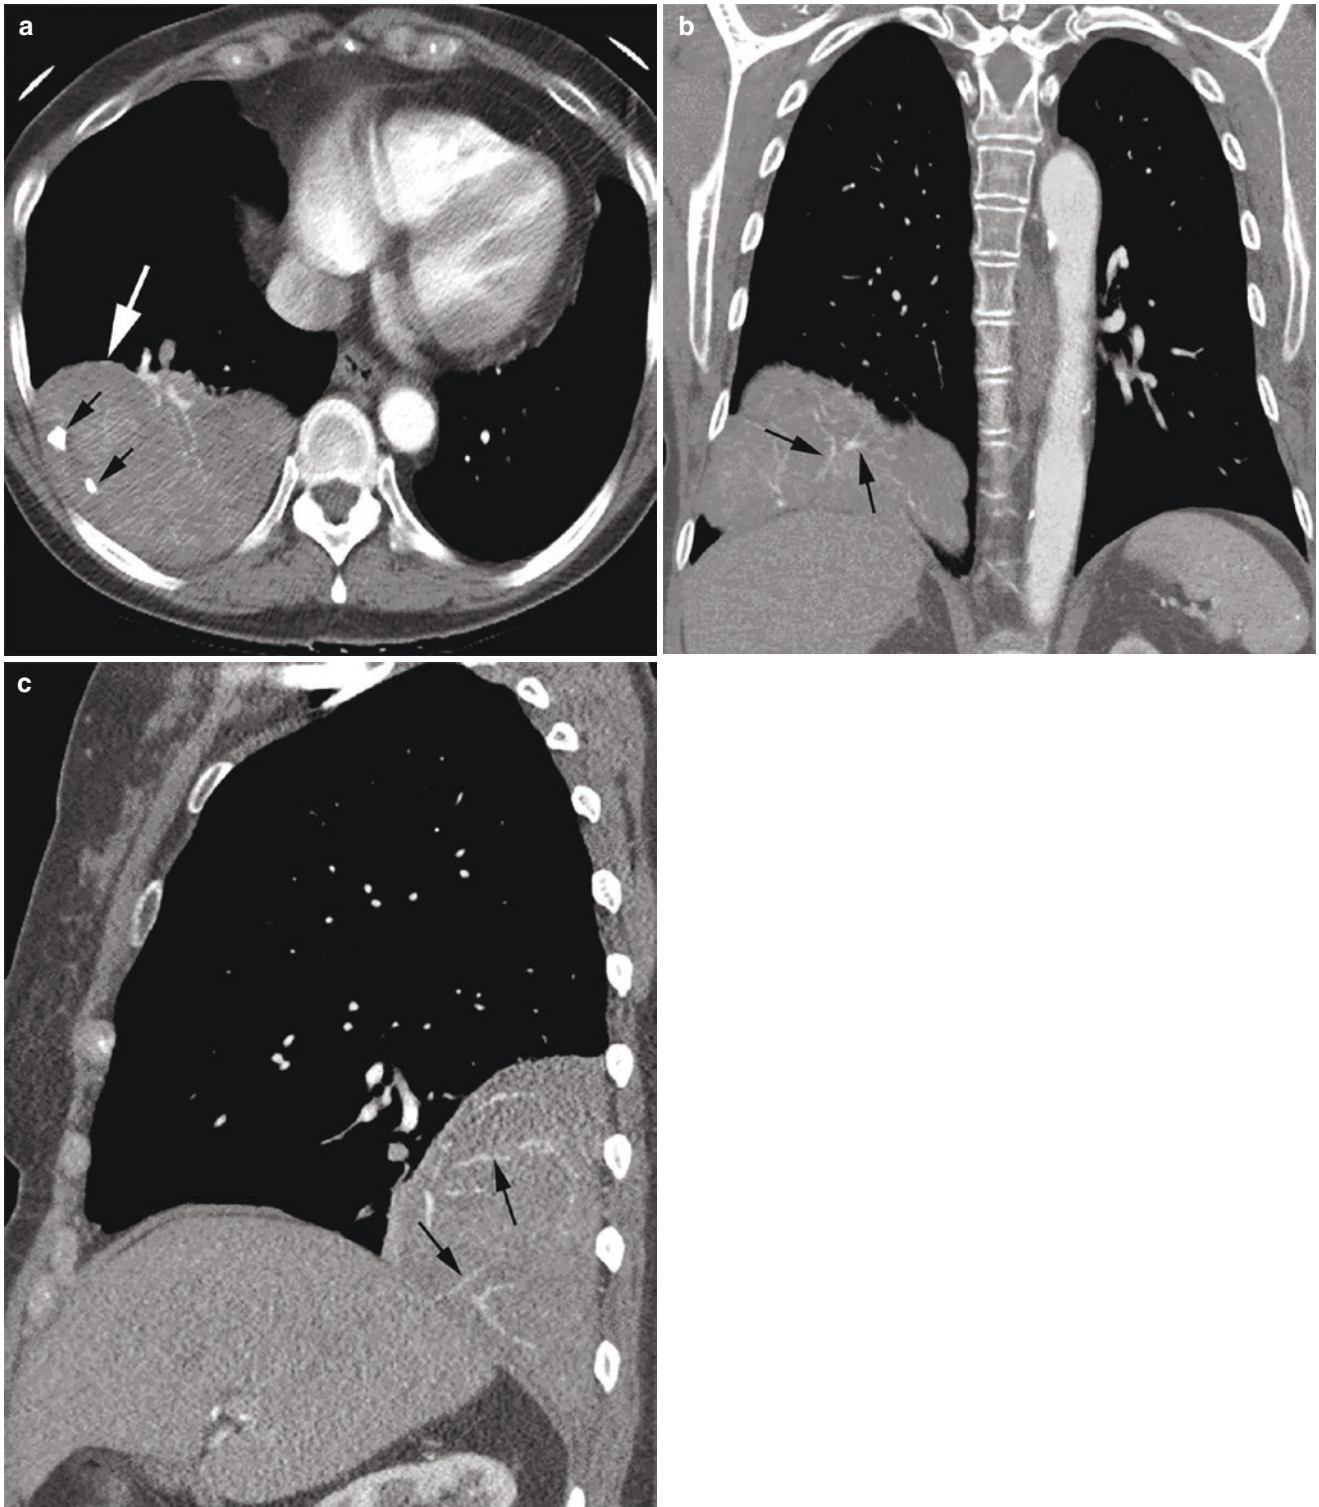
(a) Axial CT shows peripheral soft tissue mass (big arrow) in the right lower hemithorax with foci of calcification (small arrows), (b, c) coronal and sagittal CT reformations show prominent vessels within the mass (arrows)
